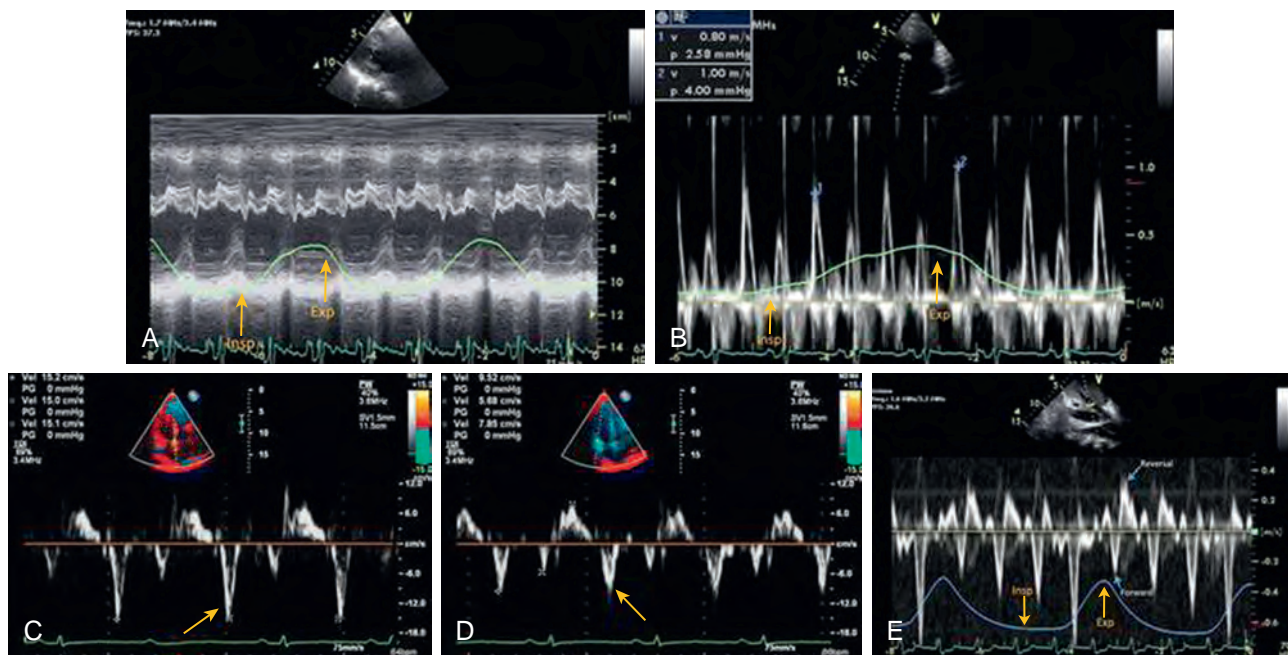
Echocardiographic findings associated with constrictive pericarditis. (A) Transthoracic echocardiography parasternal long-axis M-mode demonstrates leftward septal motion with inspiration. (B) Pulsed-wave Doppler imaging at the mitral valve leaflets demonstrates inspiratory decrease and expiratory increase of early inflow velocity. (C) Medial and (D) lateral mitral annular tissue-Doppler images record increased early relaxation velocity (e') with medial velocity exceeding lateral velocity. (E) Pulsed-wave Doppler within hepatic veins demonstrates flow reversal during expiration. Exp, Expiration; Insp, inspiration. (Reproduced with permission from Welch TD, Oh JK. Constrictive pericarditis: old disease, new approaches. *Curr Cardiol Rep.* 2015;17:20.)
